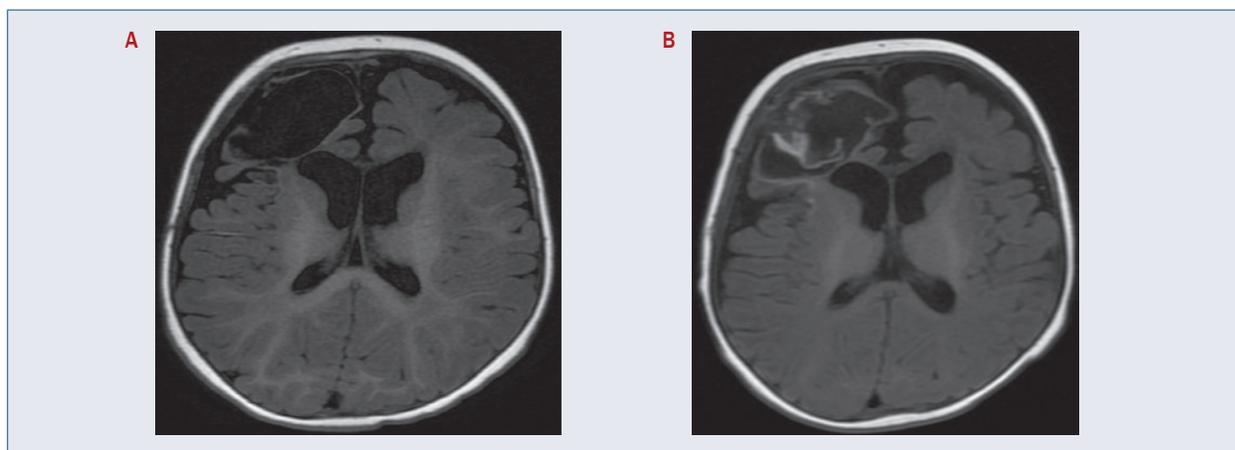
Brain magnetic resonance imaging (MRI): correct evolution of post-hemorrhagic changes
